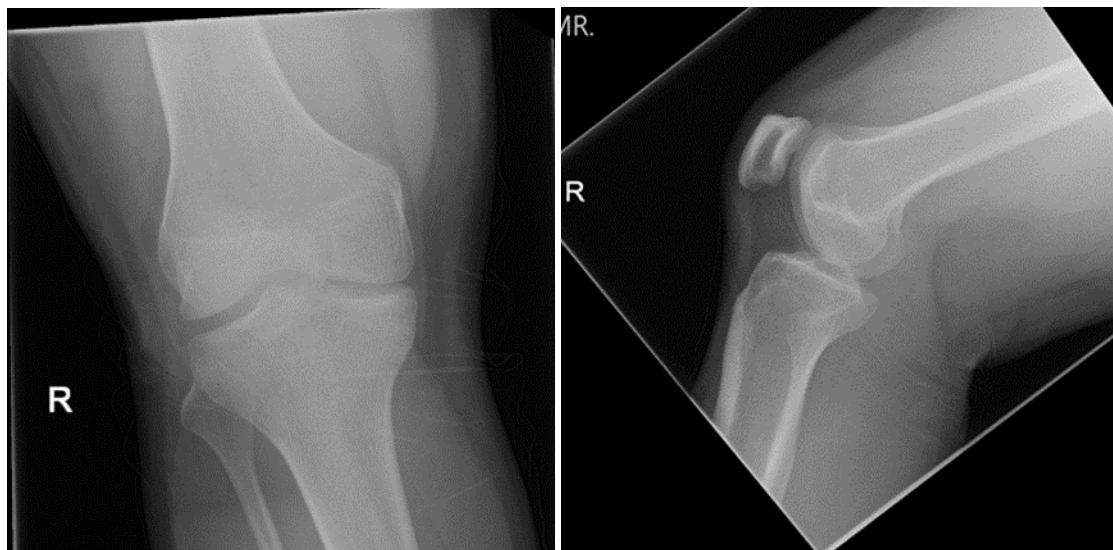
Initial Knee X-ray taken during the Initial Consultation
